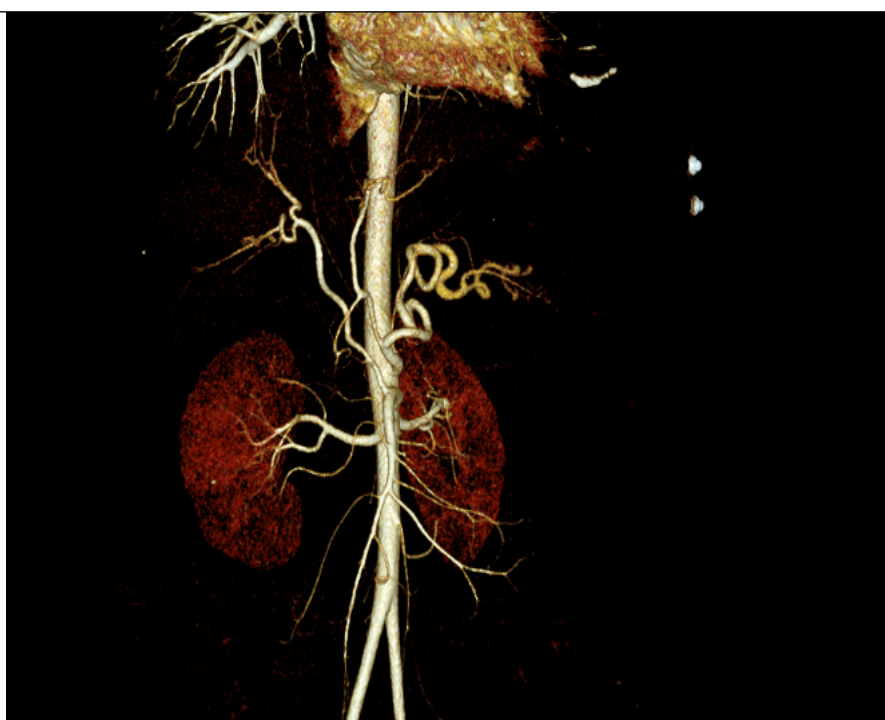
CT scan reconstruction.
